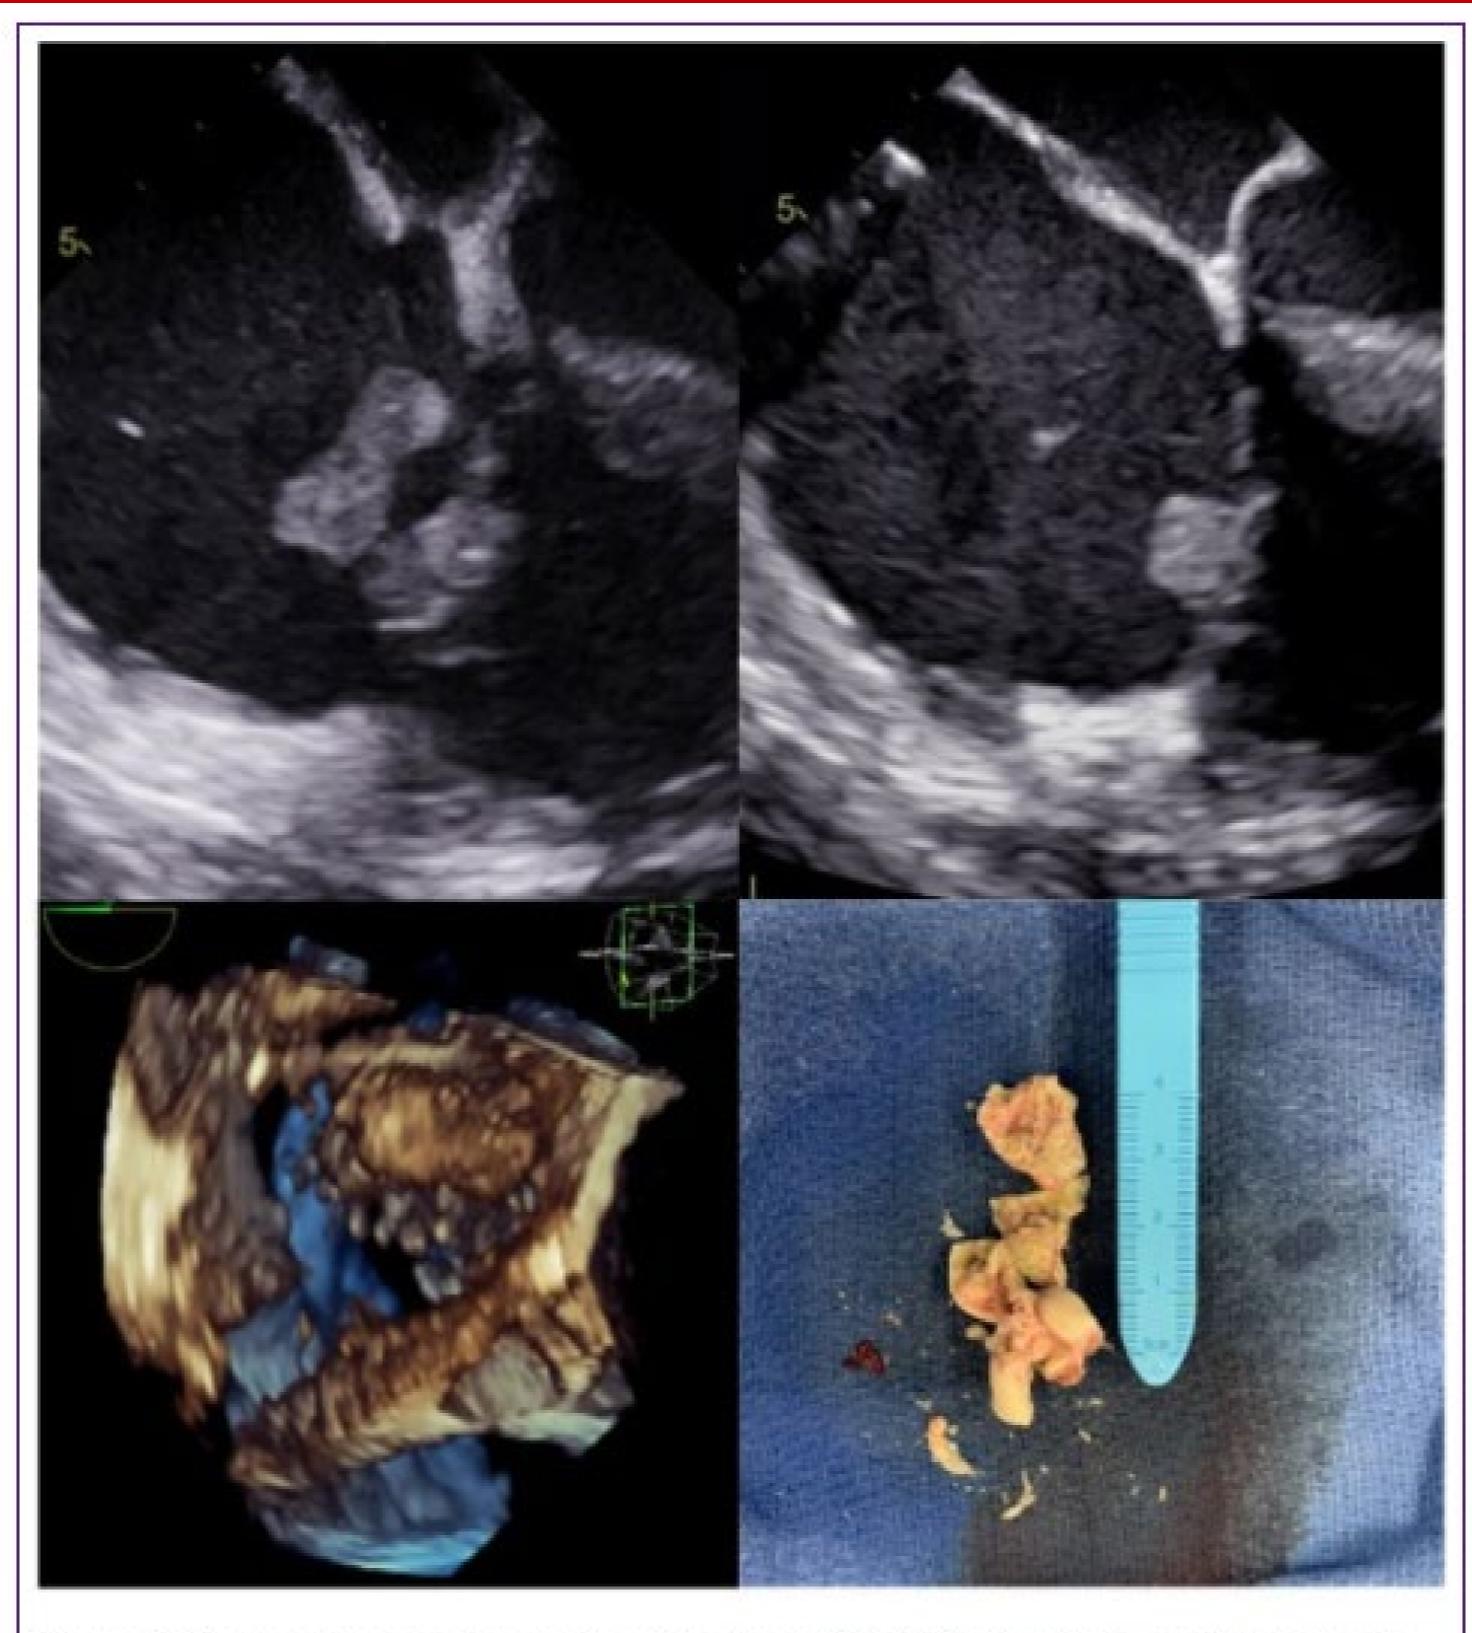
Transesophageal echocardiographic images (TEE) for visualization of the tricuspid valve with large vegetation present on the atrial aspect of the anterior and/or posterior leaflets and post-operative gross pathology. A) Pre-extraction TEE in the mid-esophageal view showing a large, 3-centimeter by 2.1-centimeter mobile, hyperechoic lesion at the level of the tricuspid valve. B) Post-extraction TEE in the mid-esophageal view showing a 1.2-centimeter by 1.1centimeter mobile, hyperechoic lesion at the level of the tricuspid valve with marked reduction in size following debulking. C) 3D reconstruction of TEE images in cross-section of intra-atrial septum showing tricuspid valve vegetation. D) Gross pathology of large valvular vegetation after debulking of tricuspid valve using AngioVac system.
